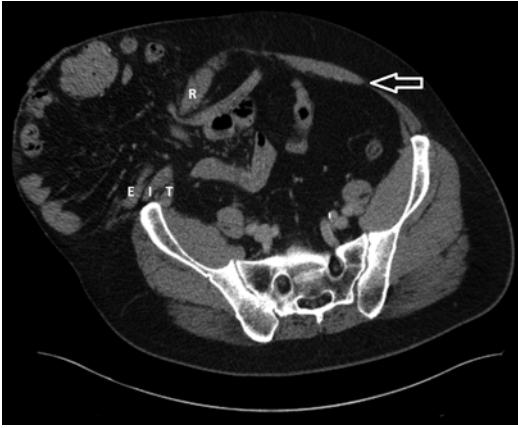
Computed Tomography of a parastomal hernia with loss of domain. The patient's main risk factor for hernia formation was the formation of his end ileostomy through the linea semilunaris. The ostomy disconnected the rectus abdominis (R) from the external oblique (E), internal oblique (I), and the transversus abdominis (T) muscles. The thin contralateral linea semilunaris can also be appreciated (arrowhead)
